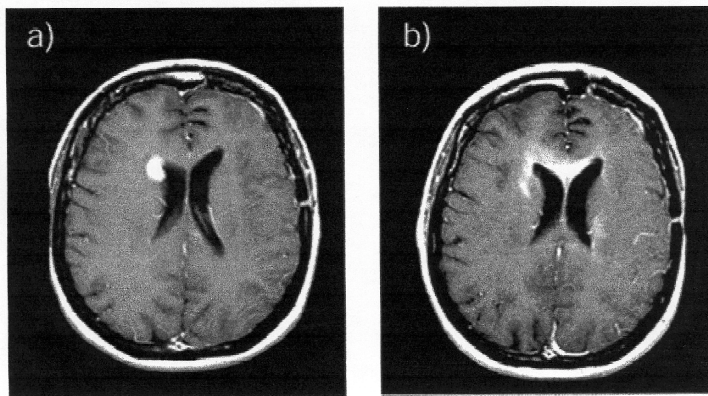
Patient example for which chemotherapy resulted in the disappearance of the contrast enhancing portion of the lesion lying in grey matter, shown in a), while the tumor continued to invade peripherally through the white matter corpus callosum, shown in b). The gadolinium-enhanced T1-weighted MRI's, shown here for this patient: a) before treatment and b) following three weeks of treatment.
